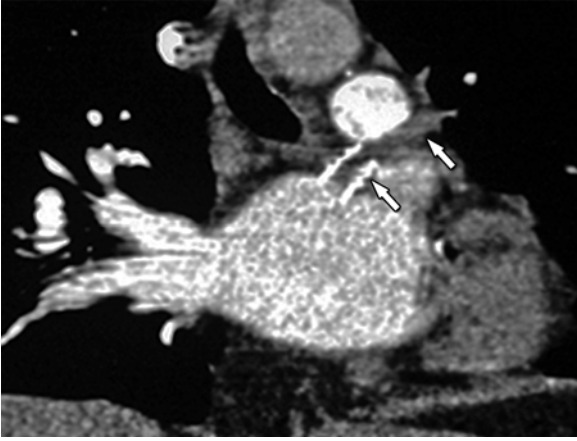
A thrombosed stent at the atriovenous junction of the upper left pulmonary vein (arrows) is seen on a slightly oblique coronal reformation image in a middle-aged man. After radiofrequency ablation for paroxysmal atrial fibrillation, the patient developed a significant stenosis in the upper left pulmonary vein. While this was initially successfully corrected with a stent, complete stent thrombosis occurred after just a few weeks. Stent restenosis and thrombosis in a pulmonary vein is a disappointingly frequent finding, occurring in up to 50% of cases. New onset or rapid deterioration of clinical symptoms is the main indication for an intervention. While a mild stenosis may be closely followed with repeat CT examinations at 3–6 months, an approximately 90% stenosis must be treated promptly as it may progress to total occlusion in 3–6 weeks. There are diverse opinions about the need for routine stent implantation in pulmonary vein stenosis, with varying strategies between centers. During the intervention, the hemodynamic significance of a stenosis can be assessed by intracardiac ultrasound-derived transstenotic velocity (usually >1.0–1.6 m/s) and catheter-measured pressure gradient (10–12 mmHg for significant stenosis), with angiography further documenting the stenosis length and morphology. Some centers perform balloon dilation alone as initial treatment with close follow-up using CT. If restenosis occurs, then stent implantation is performed. It is important to realize that pulmonary veins which appear completely occluded on CT can still have a small patent lumen on subselective pulmonary angiography. This is an important difference, as a completely occluded vein markedly decreases the success rate of any intervention
